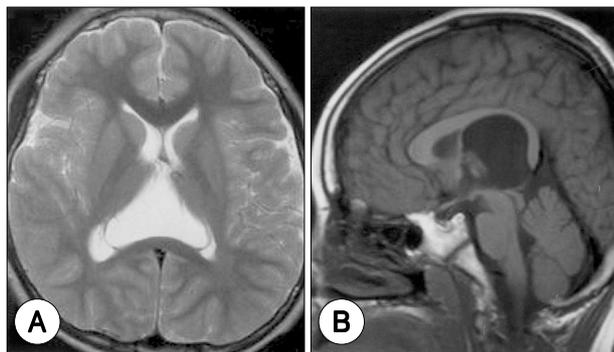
A : T₂-weighted axial magnetic resonance (MR) imaging revealing a 3 × 4cm sized cyst occupying the cistern of the velum interpositum. It has a triangular configuration on the axial plane, with the anterior apex at the level of the foramen of Monro and posterolateral extremities at the level of the choroid plexus of the lateral ventricles. The cyst wall was clearly visible. B : T₁-weighted sagittal MR image showing that quadrigeminal plate is mildly displaced inferiorly and posterior part of corpus callosum is mildly compressed by cyst.
